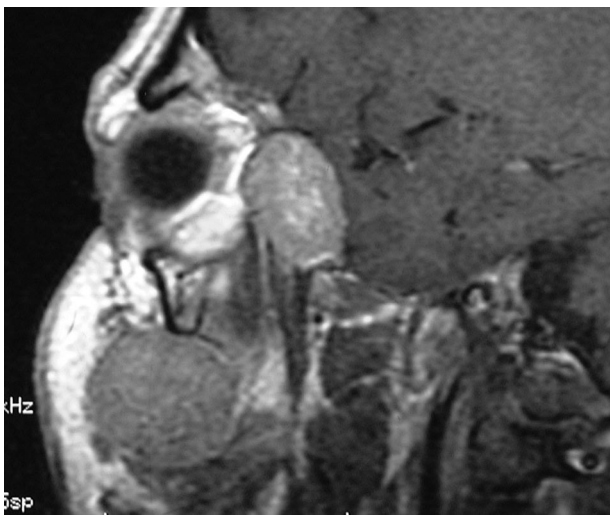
Sagittal T₁-weighted MRI demonstrating orbital and cheek tumors.
